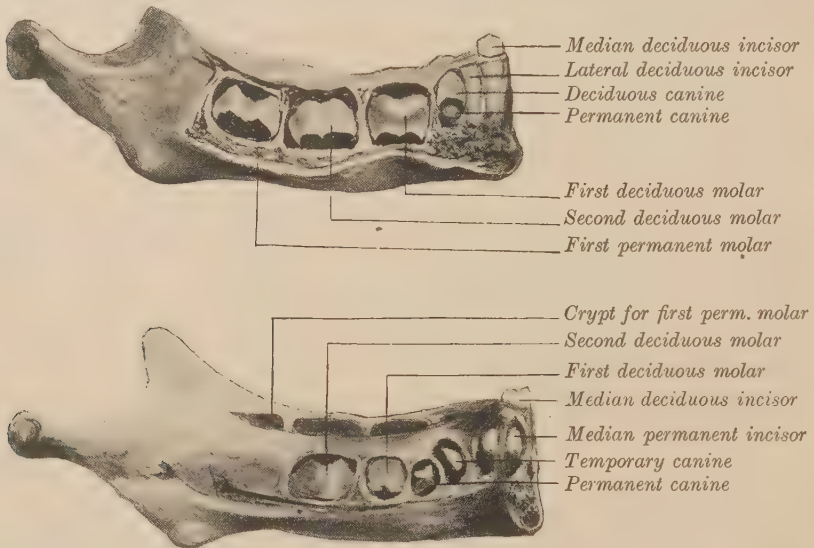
MANDIBLE OF CHILD AGED EIGHT MONTHS, WITH TEETH EXPOSED ON RIGHT HALF FROM THE LATERAL ASPECT AND ON THE LEFT FROM THE MEDIAN ASPECT. Natural size. (J. Howard Mummery.)
